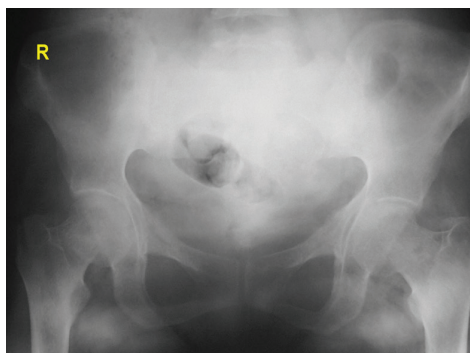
Pre-operative antero-posterior pelvic X-ray of the second case. R: Right side
